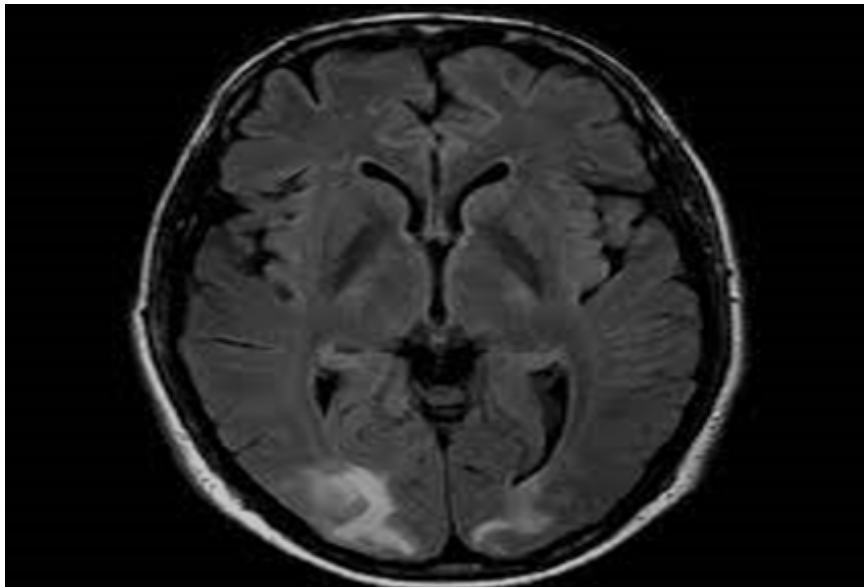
Brain MRI showing confluent posterior occipital hypodense white matter representative of PRES.
